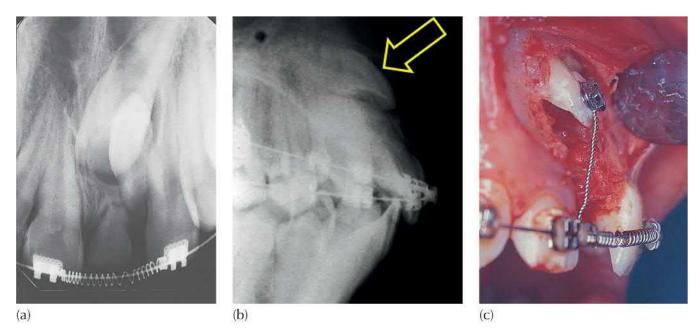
(a) The periapical view shows an impacted left maxillary central incisor, due to an inverted, unerupted, supernumerary tooth. The deciduous tooth is over-retained. Accurate diagnosis of the height of the impacted tooth in the alveolus is not possible to determine from this view. (b) The anterior maxilla seen on a lateral cephalometric radiograph shows the high impacted central incisor (arrow) and its bucco-lingual location, facing the labial vestibular sulcus. (c) The parallel intra-oral photographic view at surgical exposure. The radiograph has been laterally inverted to simplify comparison.
